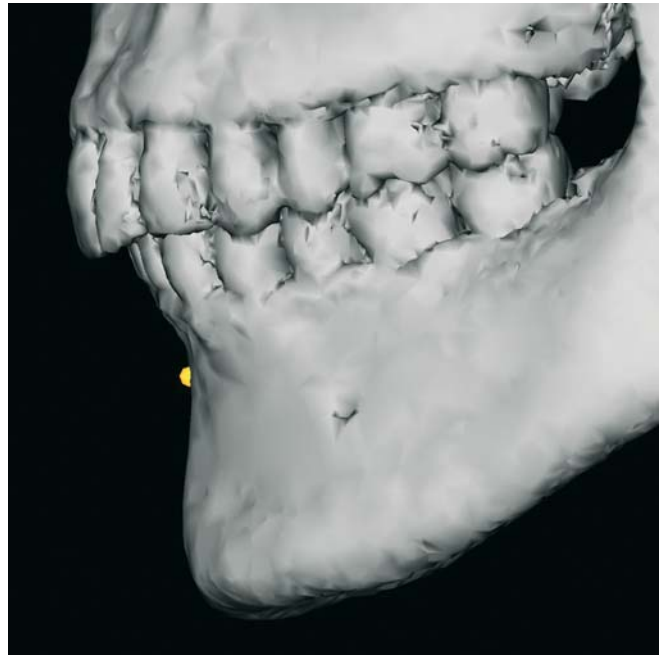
B-Point. Profile view left (3-D CT, patient K.C.)
